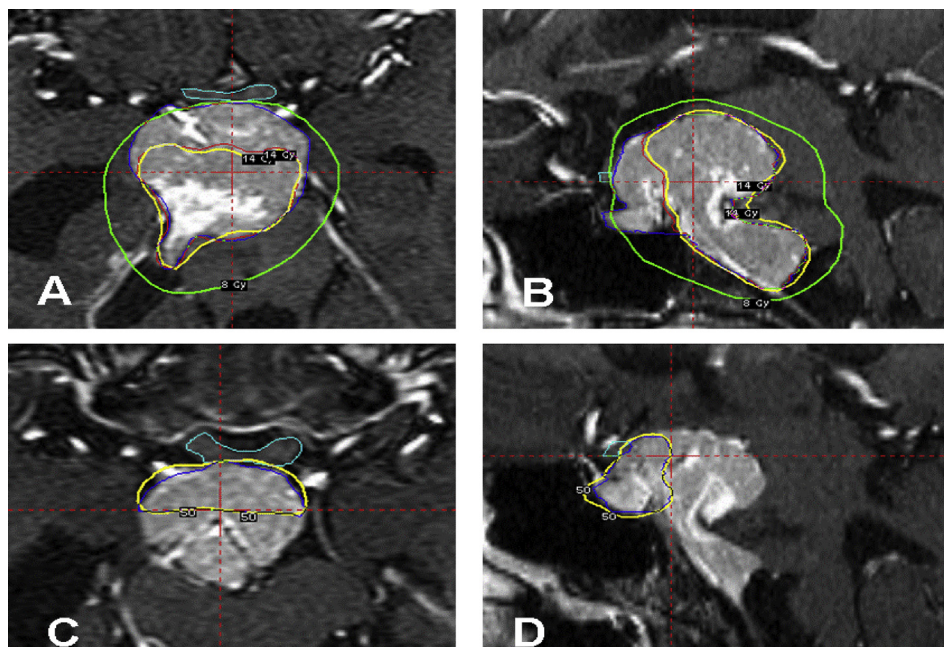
Case 3. (A) Axial and (B) sagittal MR images showing the large basal mass encased by the 14 Gy isodose line (yellow) during the first stage of the snowman strategy, with the 8 Gy isodose line (green) just touching the chiasm (blue); (C) axial and (D) sagittal MR images showing the smaller, more anterior tumor treated with a less adequate dose in the first stage encased in the 8 Gy isodose line during the second stage of the snowman strategy, with the dose of the chiasm lower than 8 Gy as much as possible.
